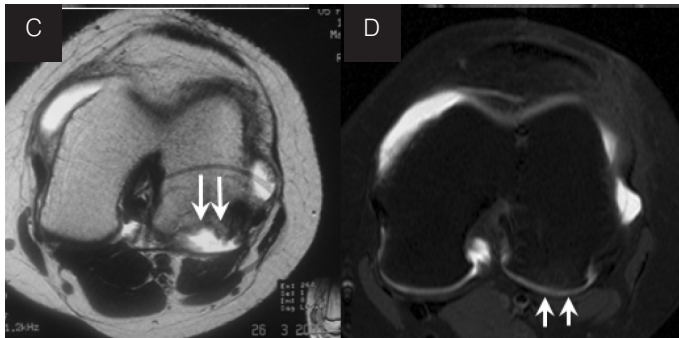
A) X-ray image of the knee at anteroposterior plane, showing the loose osteochondral body. B) X-ray image of the knee at sulcus plane where the dissecting osteochondritis lesion can be seen at the lateral femoral condyle. C) Magnetic resonance image of the knee showing a dissecting osteochondritis lesion at the lateral femoral condyle. D) Magnetic resonance image of the knee showing an osteochondral loose body at medial synovial recess.
